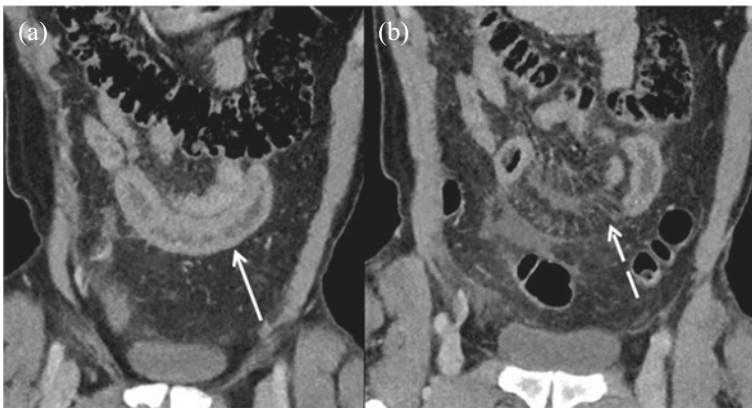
A 20 year old man with known Crohn's disease presents with increased frequency of bowel motions, blood and mucous per rectum, pyrexia, tachycardia and raised CRP. Coronal contrast-enhanced CT abdomen/pelvis demonstrates wall thickening in the terminal ileum (image A-solid arrow) and the 'mesenteric comb sign' (image B-dashed arrow). Findings are consistent with active inflammation
